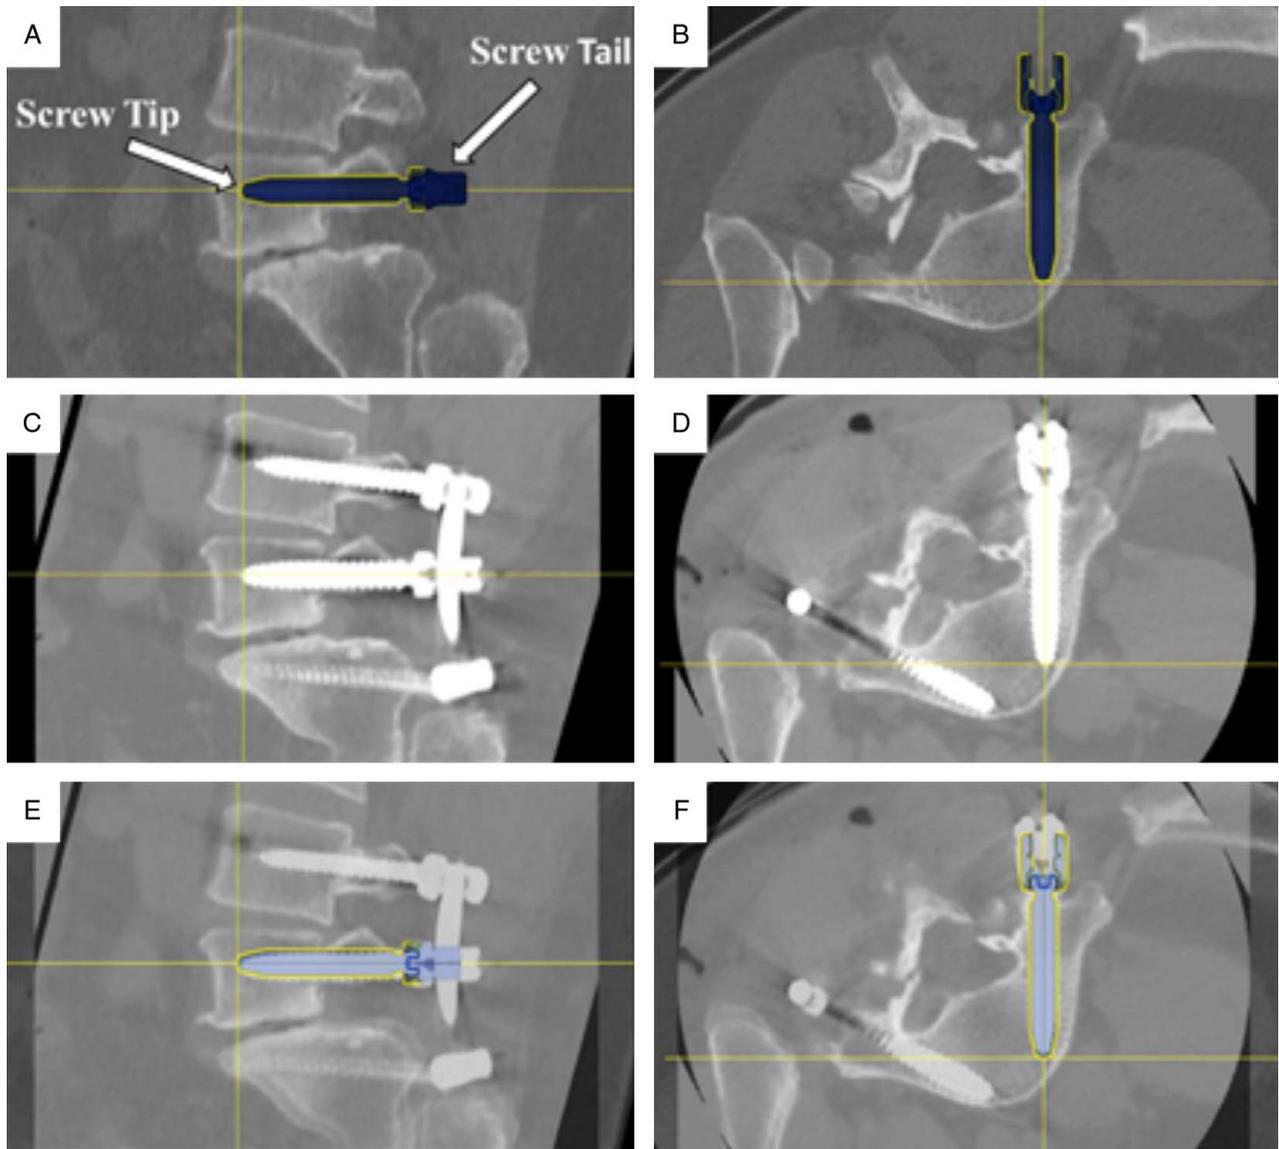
Screw tip, tail, and angle deviation assessment. Right L5 screw planning in sagittal (A) and axial (B) planes. Postoperative computed tomography of L5 screw placement in sagittal (C) and axial (D) planes. Image overlay analysis with preoperatively planned trajectory and postoperative screw placement in sagittal (E) and axial (F) planes. The cross-hairs indicate screw tip. [full color online](#)
